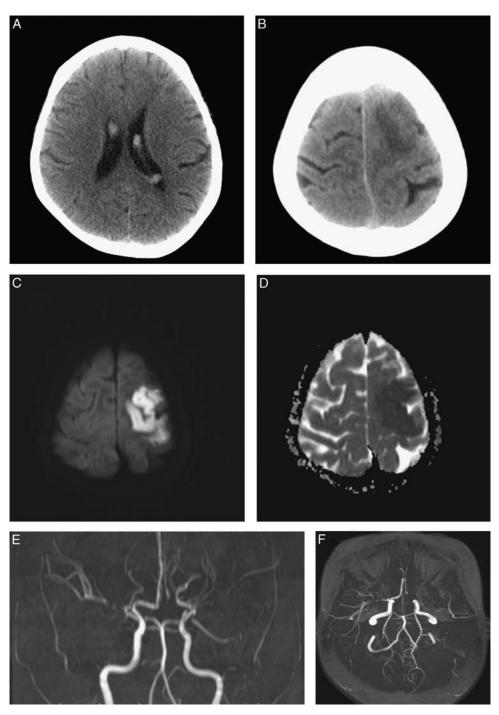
(A and B) Initial head computed tomography scan showed acute intraventricular hemorrhage and cerebral infarction of left middle cerebral artery territory. (C and D) Initial brain magnetic resonance imaging: diffusion-weighted imaging found high signal on left middle cerebral artery territory, and apparent diffusion coefficient discovered low signal on the same part. (E and F) Magnetic resonance angiography showed occlusion of bilateral proximal portion of the anterior and middle cerebral arteries, and these occluded vessels are surrounded by numerous small vessels.
